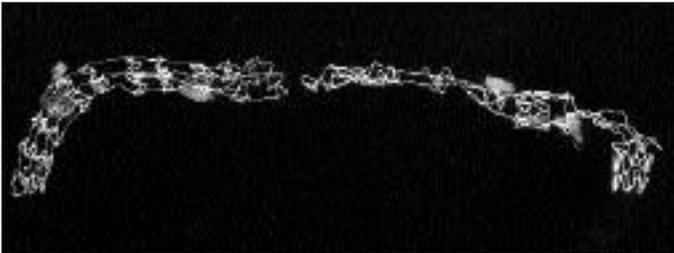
This radiograph shows the piece of endarterectomy including two stents
